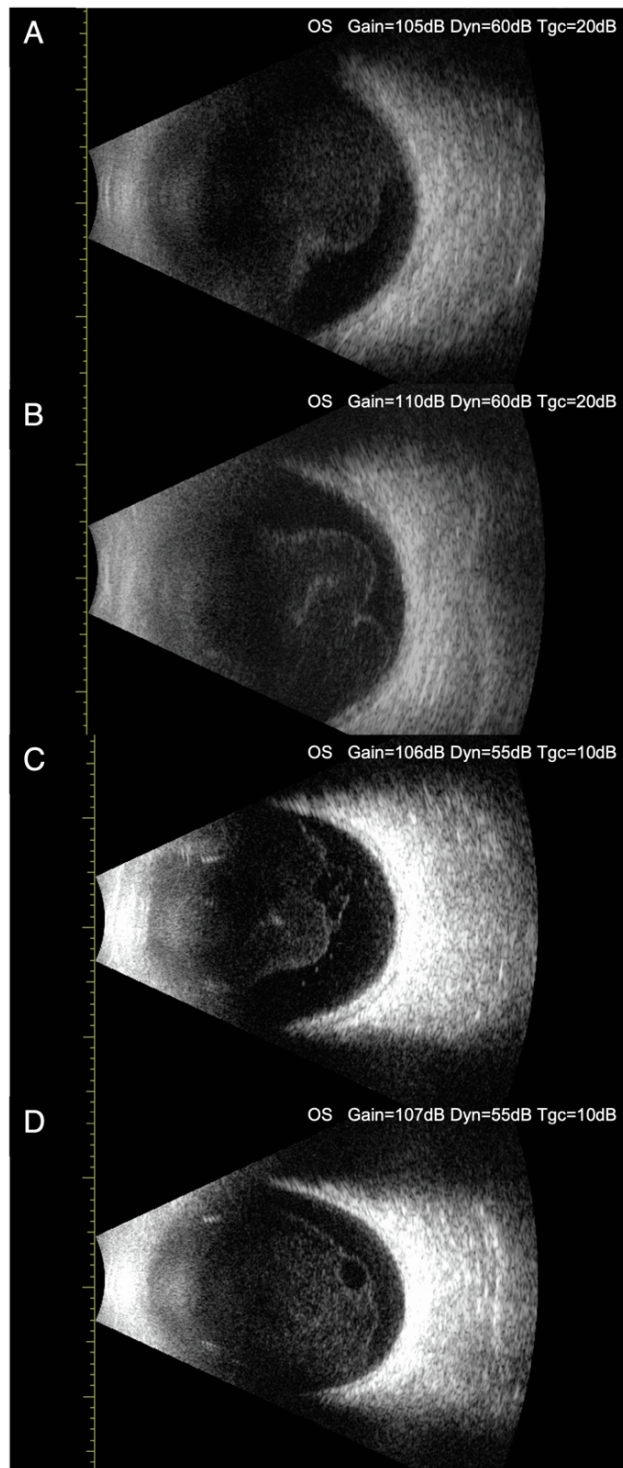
Postoperative B-scan ultrasonography of patient 3. B-scan ultrasonography of the patient 3 on 7 days (A), 1 month (B), 3 months (C) and 6 months (D) post-injection. Continuous ribbon-like echo was found in the posterior vitreous body, indicating vitreous opacity with posterior detachment.
